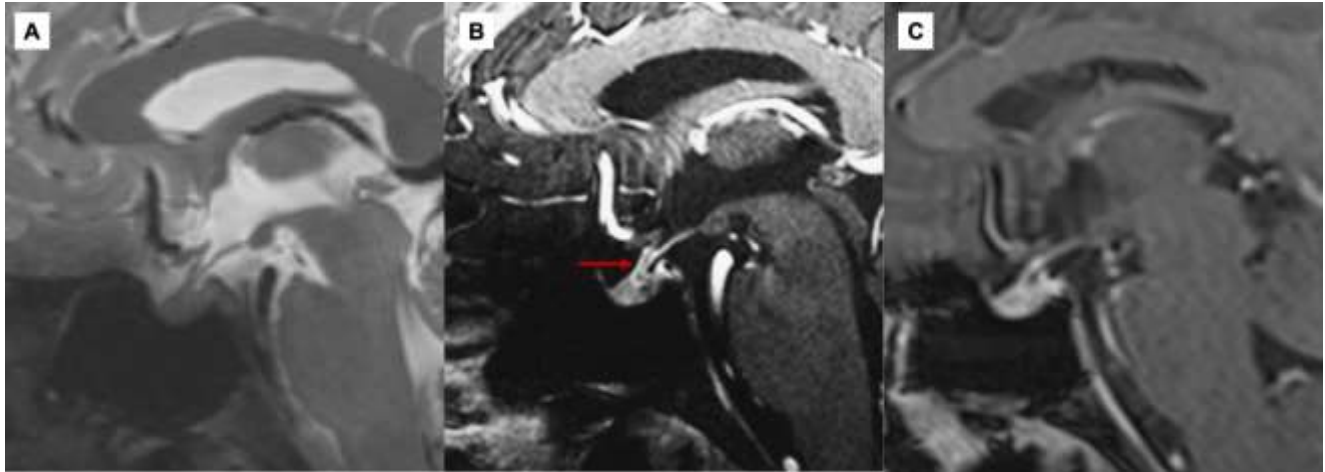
A 37-year-old male with medically refractory epilepsy and prior temporal lobectomy was referred to 7T MRI for follow-up. A) Sagittal pre-contrast 3D-T₂-SPACE does not show any abnormality in the pituitary gland, and the lesion pointed out with the red arrow in B is not visible. B) Sagittal post-contrast 3D-FS-T₁ MPRAGE at 7T shows string-like C-shaped hypointensity extending from the stalk all the way through the adenohypophysis (red arrow), favored as Rathke's cleft. C) Sagittal contrast-enhanced 3D T₁ MPRAGE images obtained 5 months later at 3T MRI are unable to demonstrate the presumed Rathke's cleft.
